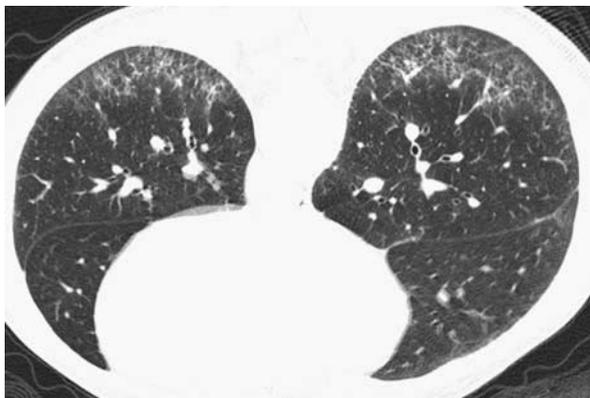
NSIP pattern in HP. Prone HRCT demonstrates a basilar predominance of irregular reticulation and GGO. The findings have a peripheral predominance, but show sparing of the immediate subpleural lung. Occasionally, HP shows findings characteristic of NSIP.
